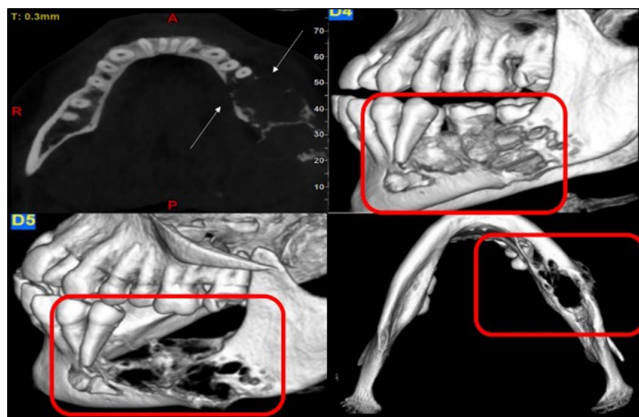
CBCT sections showing the destruction of buccal and lingual cortical plates
